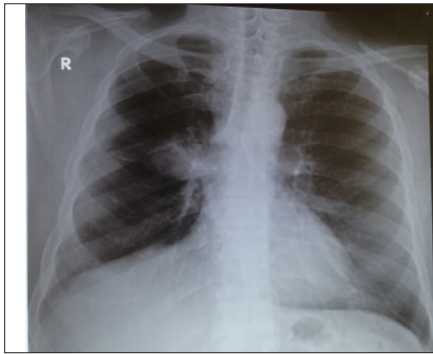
Chest X-ray shows a 4 cm mass shadow in the right perihilar region.
